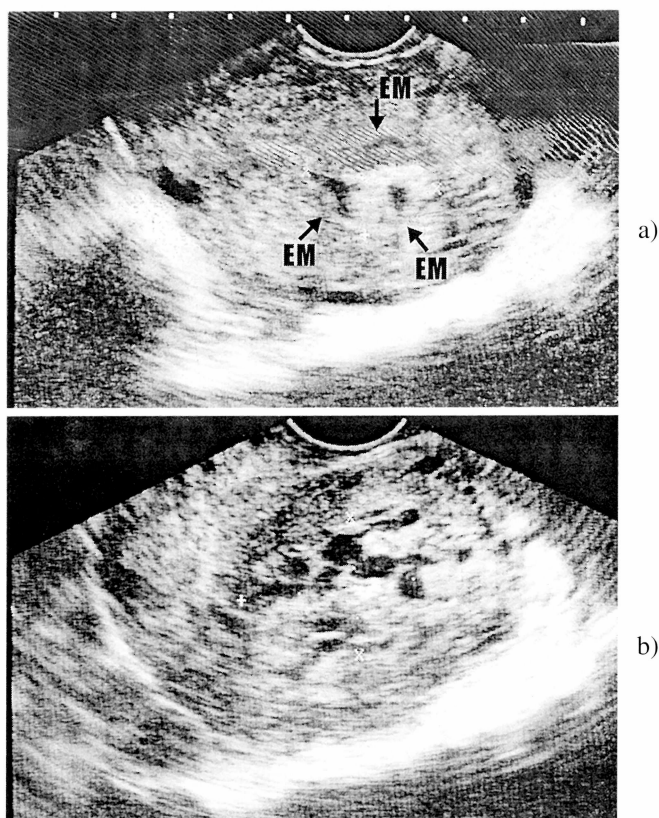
Transvaginal ultrasound (TVUS) pictures of the intrauterine complex before the second uterine evacuation.
